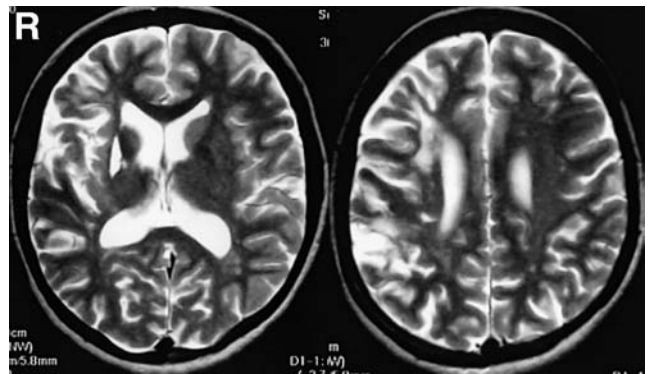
Follow-up T₂-weighted magnetic resonance images 4 years after surgery, showing old cerebral infarction in the right hemisphere, especially the watershed area and the external capsule.
